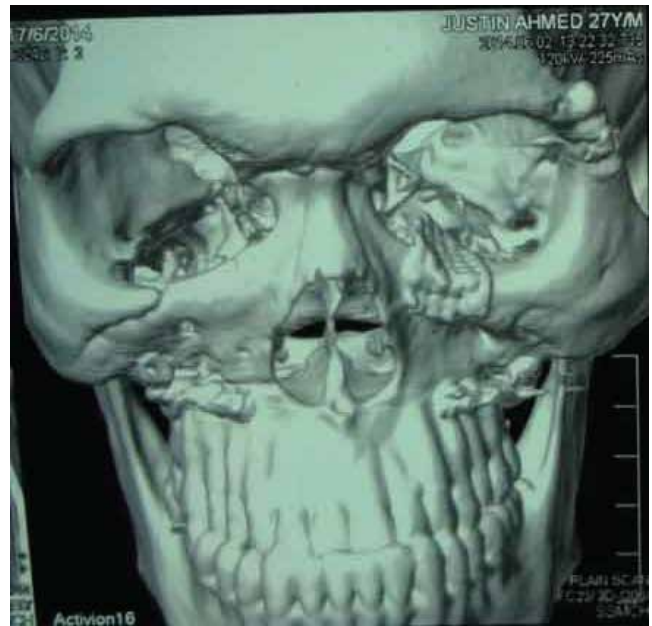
Post-operative 9 months follow-up by CT scan with 3D image showing reconstruction of the orbital floor and margin
